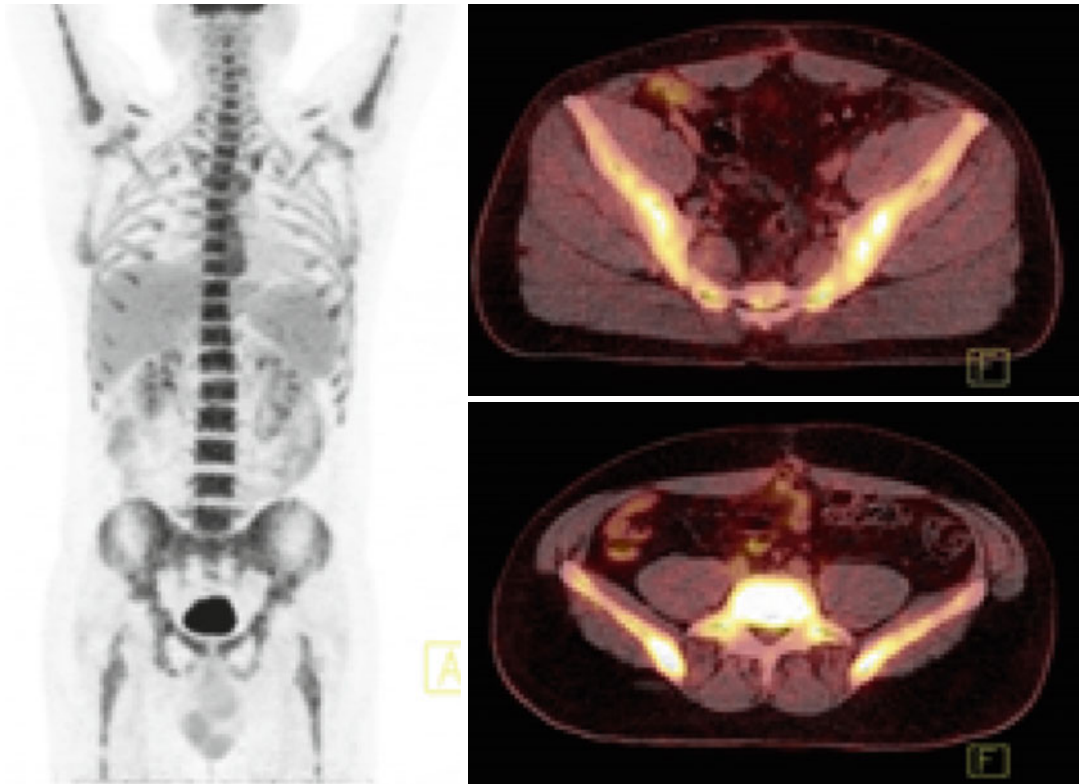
Interim PET/CT: no increased FDG activity at the sites of prior disease. Notice the diffuse increased FDG uptake at the bone marrow attributed to granulocyte
